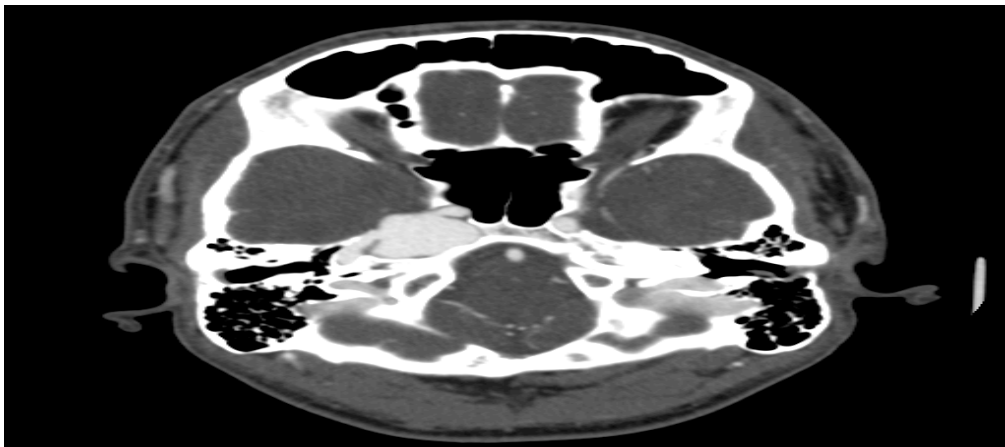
CTA head, pre-procedure
